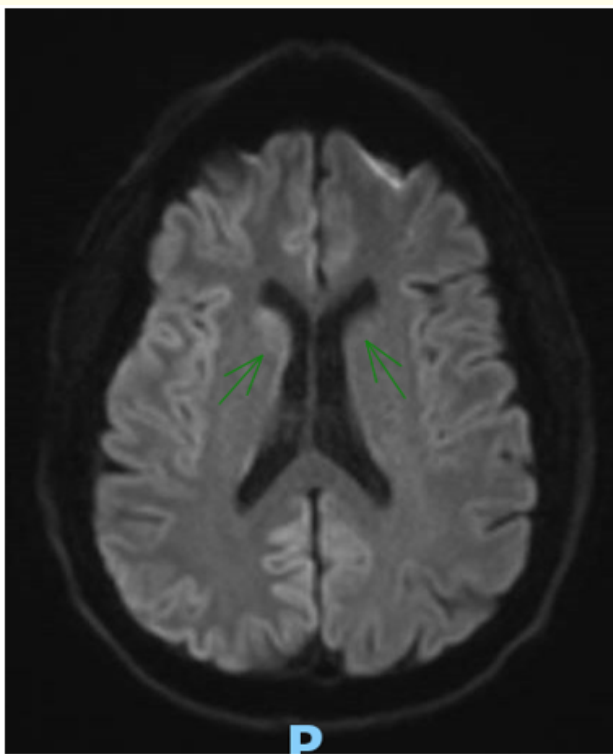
MR brain without and with IV contrast. Series Desc AX DWI (Resolve SMS TraceW).
